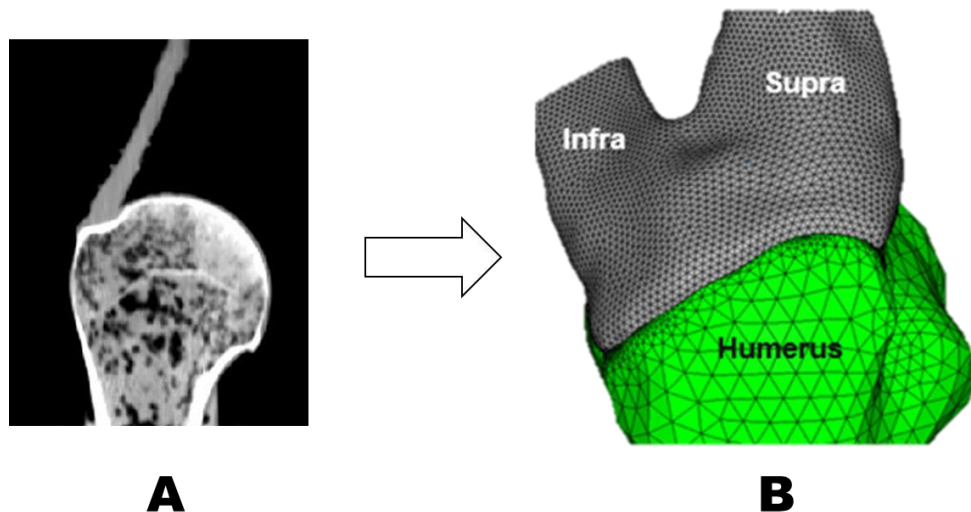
Overview of FEM model creation. CT Scans (A) were used to create model geometry (B)
